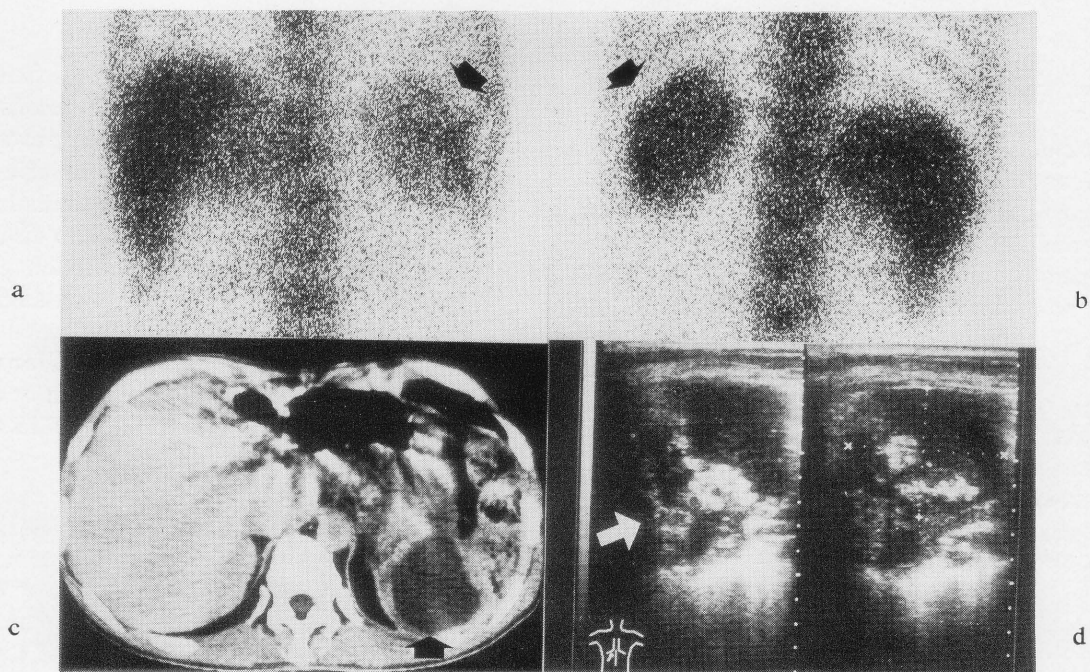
Case 3. Patient postgastrectomy and splenectomy with fever. In-111 WBC images (a. anterior view, b. posterior view) show accumulation in area of the left upper quadrant (black arrow). CT and US clearly demonstrate an abscess in that lesion (c. black arrow, d. white arrow).
